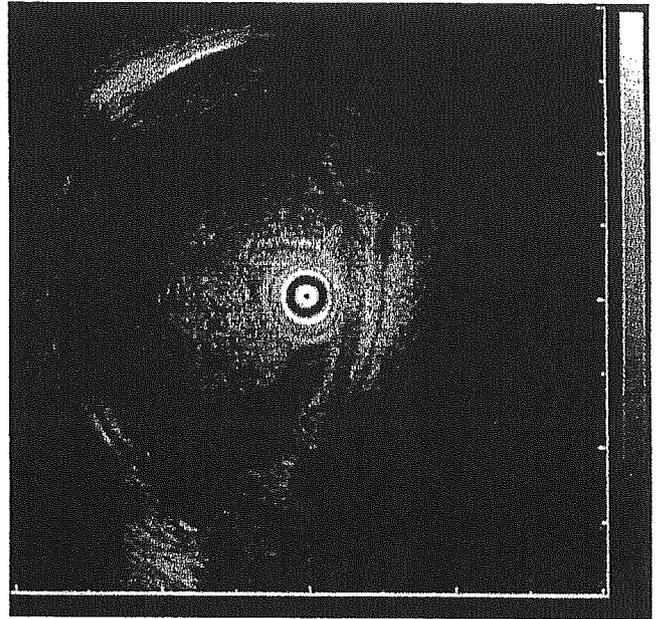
Endoscopic ultrasonography (EUS) revealed a polypoid mass with a mosaic echo pattern.
